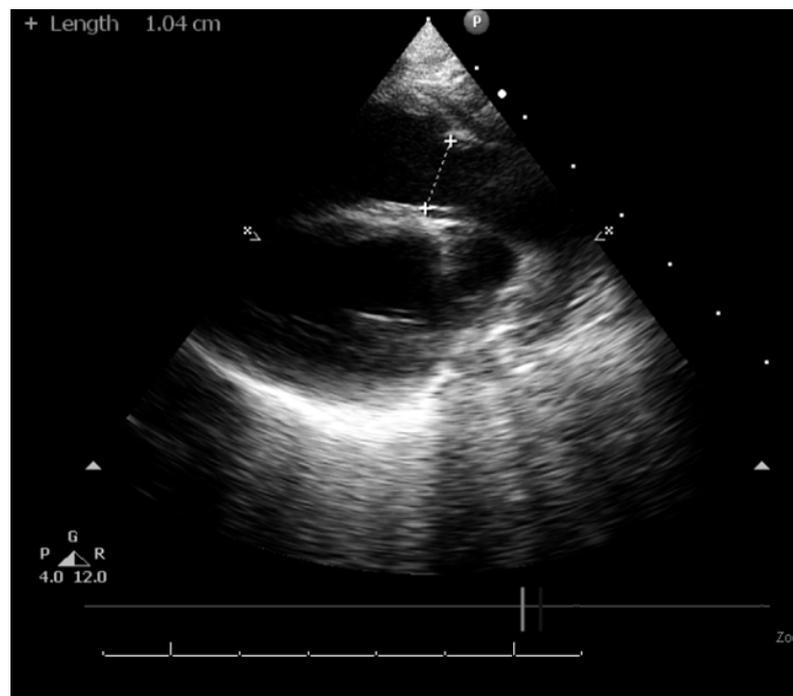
Echocardiographic measurement of RVO diameter at the level of the pulmonary valve (white line)
